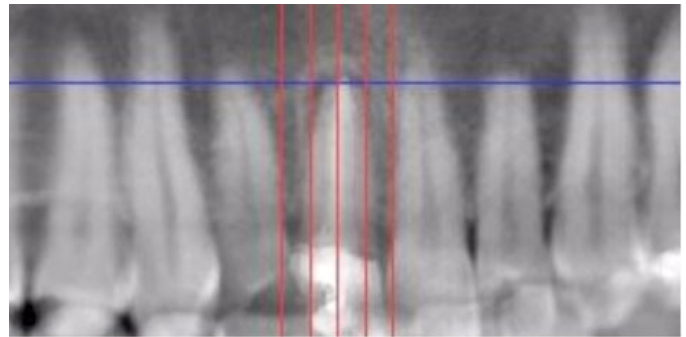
(B) Preoperative cone beam computed tomography (CBCT) scout view (panoramic) of tooth 8.
